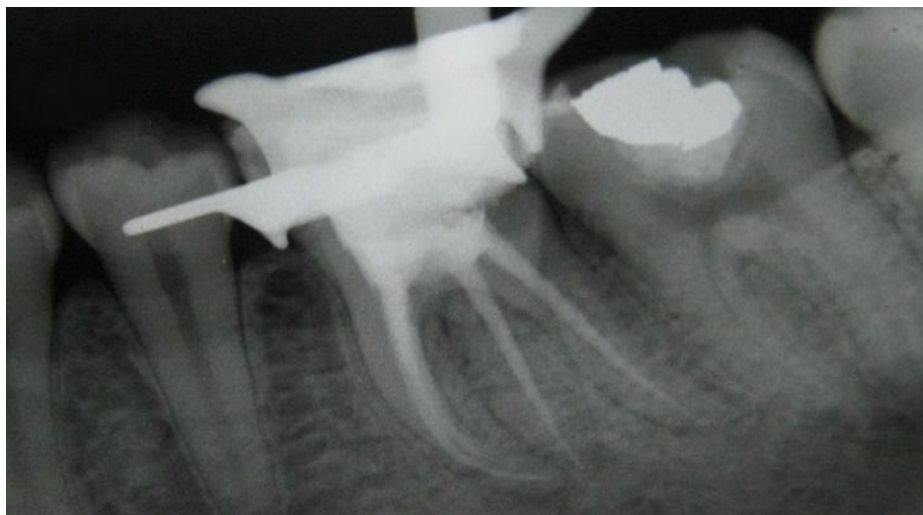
(c) Post-obturation radiograph
